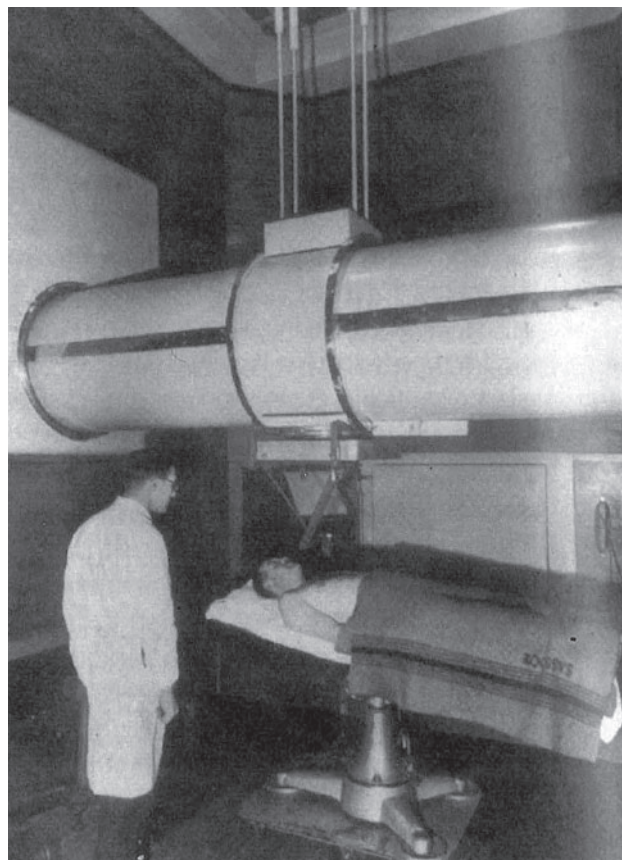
Dr Ralph Phillips and a patient to be treated using the 1-MeV therapy installation at St Bartholomew's Hospital, London. The unit created high-energy, penetrating x-rays used for treating cancers and other tumors. The immediate benefit to the patient of the tumor's eradication or reduction was generally thought to outweigh the risk of developing future cancers from the high radiation dose delivered. Reproduced from: Jones A. The development of megavoltage x-ray therapy at St. Bartholomew's Hospital. *Br J Radiol.* 1988;22(suppl):3-10. Copyright: The British Institute of Radiology (used with permission).
